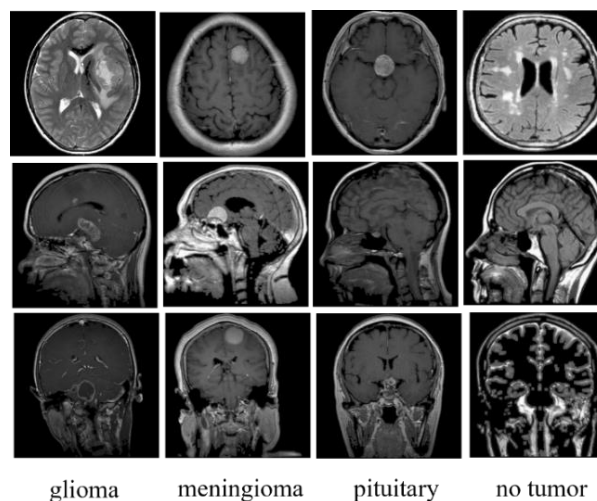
Examples of brain MRI images: glioma, meningioma, pituitary, and no tumor
